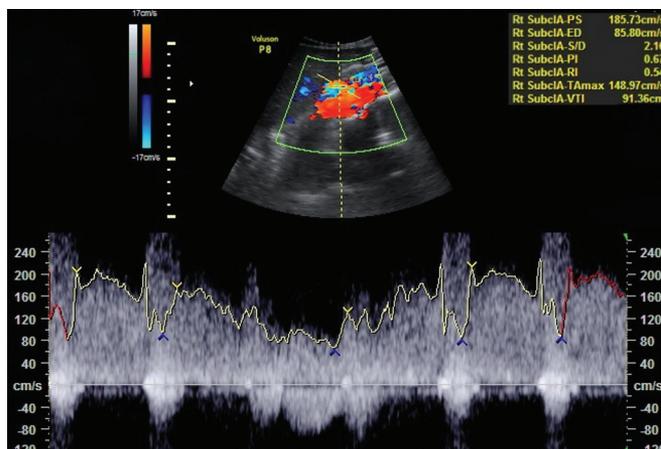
Doppler image demonstrating high peak systolic flow of celiac trunk at the site of compression
